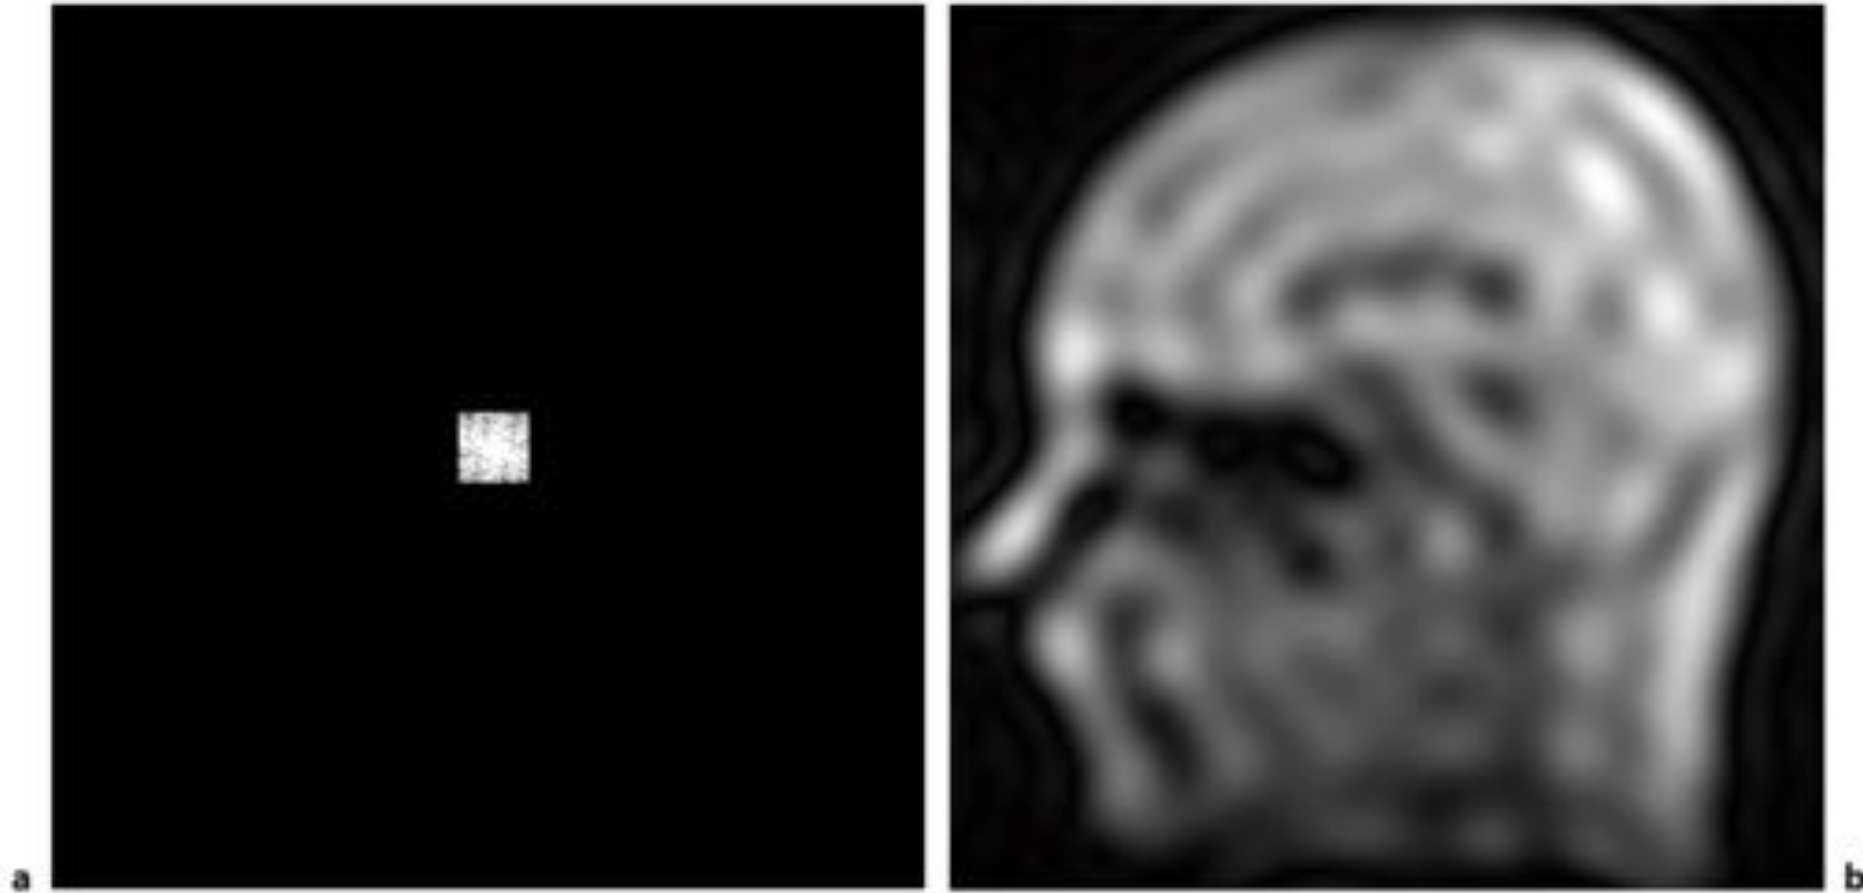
a Raw data in the center of k-space and b corresponding reconstructed MR image. The image appears filtered; only large-scale changes of intensity corresponding to low spatial frequencies remain.
